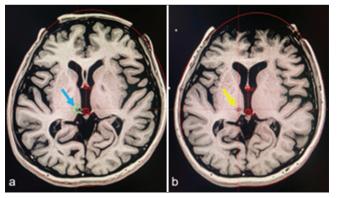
Ablative effect of GKR. (a) Sagittal slide of T1-weighted MRI planning radiation dose delivery to the right thalamus (blue arrow). (b) control image one year after treatment shows a hypointense area at the treatment site (yellow arrow) confirming the ablative effect at the level of the right posteromedial thalamus. The upper red box (AC) corresponds to the anterior limit of the intercommissural line, and the lower red box (PC) to the posterior limit.
